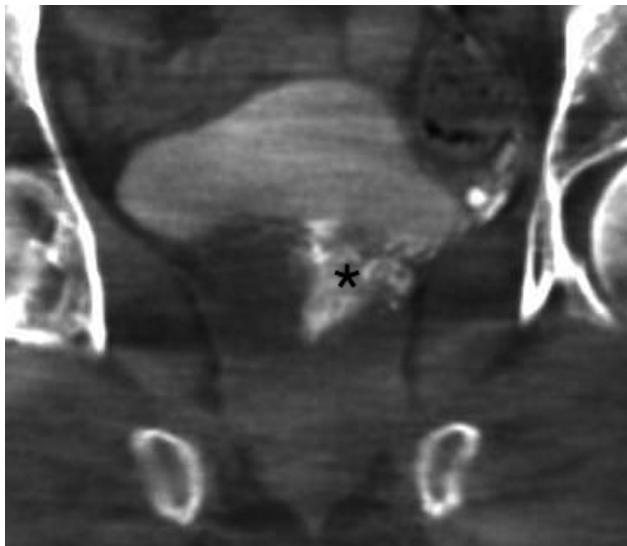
Cone-beam CT after left prostatic artery injection shows enhancement of the left hemiprostate (asterisk) corresponding to angiography and MR imaging findings.
